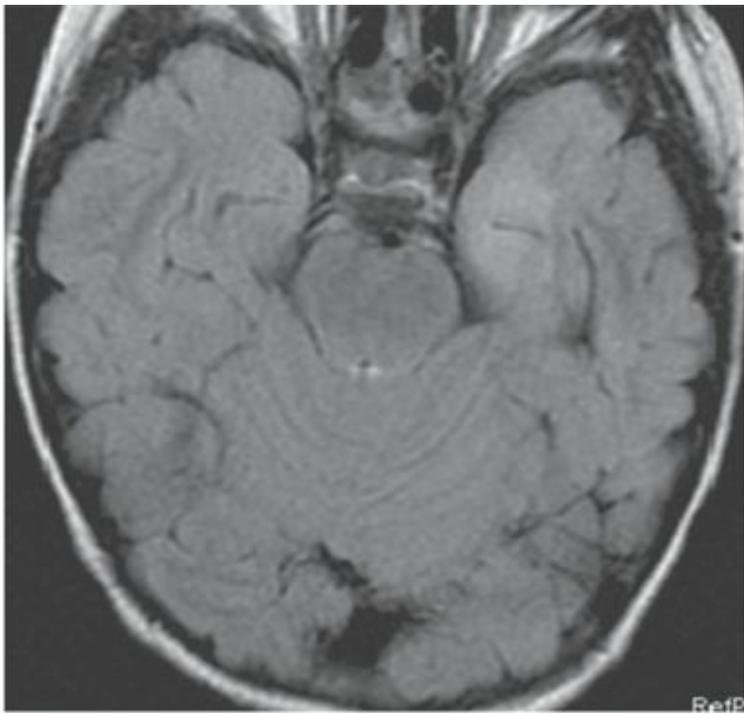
Case 3. (All images are of the same patient.) A: MRI showing left anteromedial temporal malformation of cortical development in an 11-year-old girl with history of left temporal lobe seizures from 5 to 7 years of age and then severe epileptic encephalopathy. B: FDG-PET showing severe left anteromedial hypometabolism in the region of the malformation seen in A. C: EEG at 11 years of age showing nonlocalized slow spike-and-wave complexes, nearly continuous during sleep (CSWS pattern). After left anteromedial temporal resection, she was free of seizures with resolution of her epileptic encephalopathy. Postoperative EEG showed no epileptiform discharges while awake or asleep.
